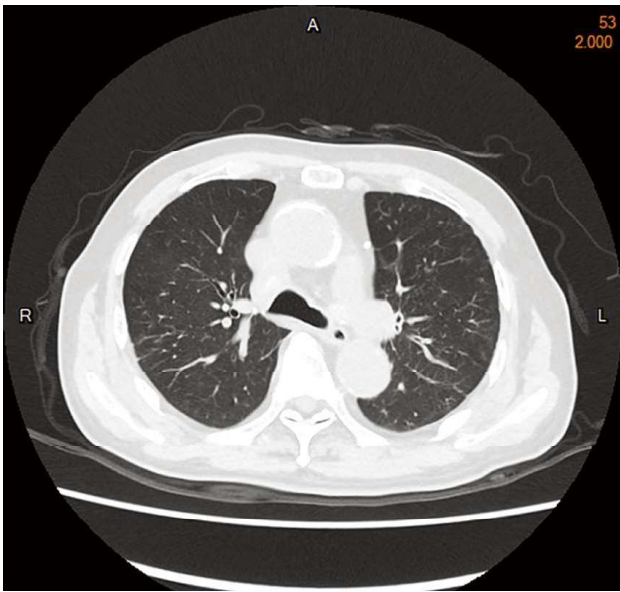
Non-contrast chest tomography (CT) showed lymphadenopathy in the pretracheal retrocaval (PTRC) region (the patient had chronic kidney disease and did not receive contrast CT).
